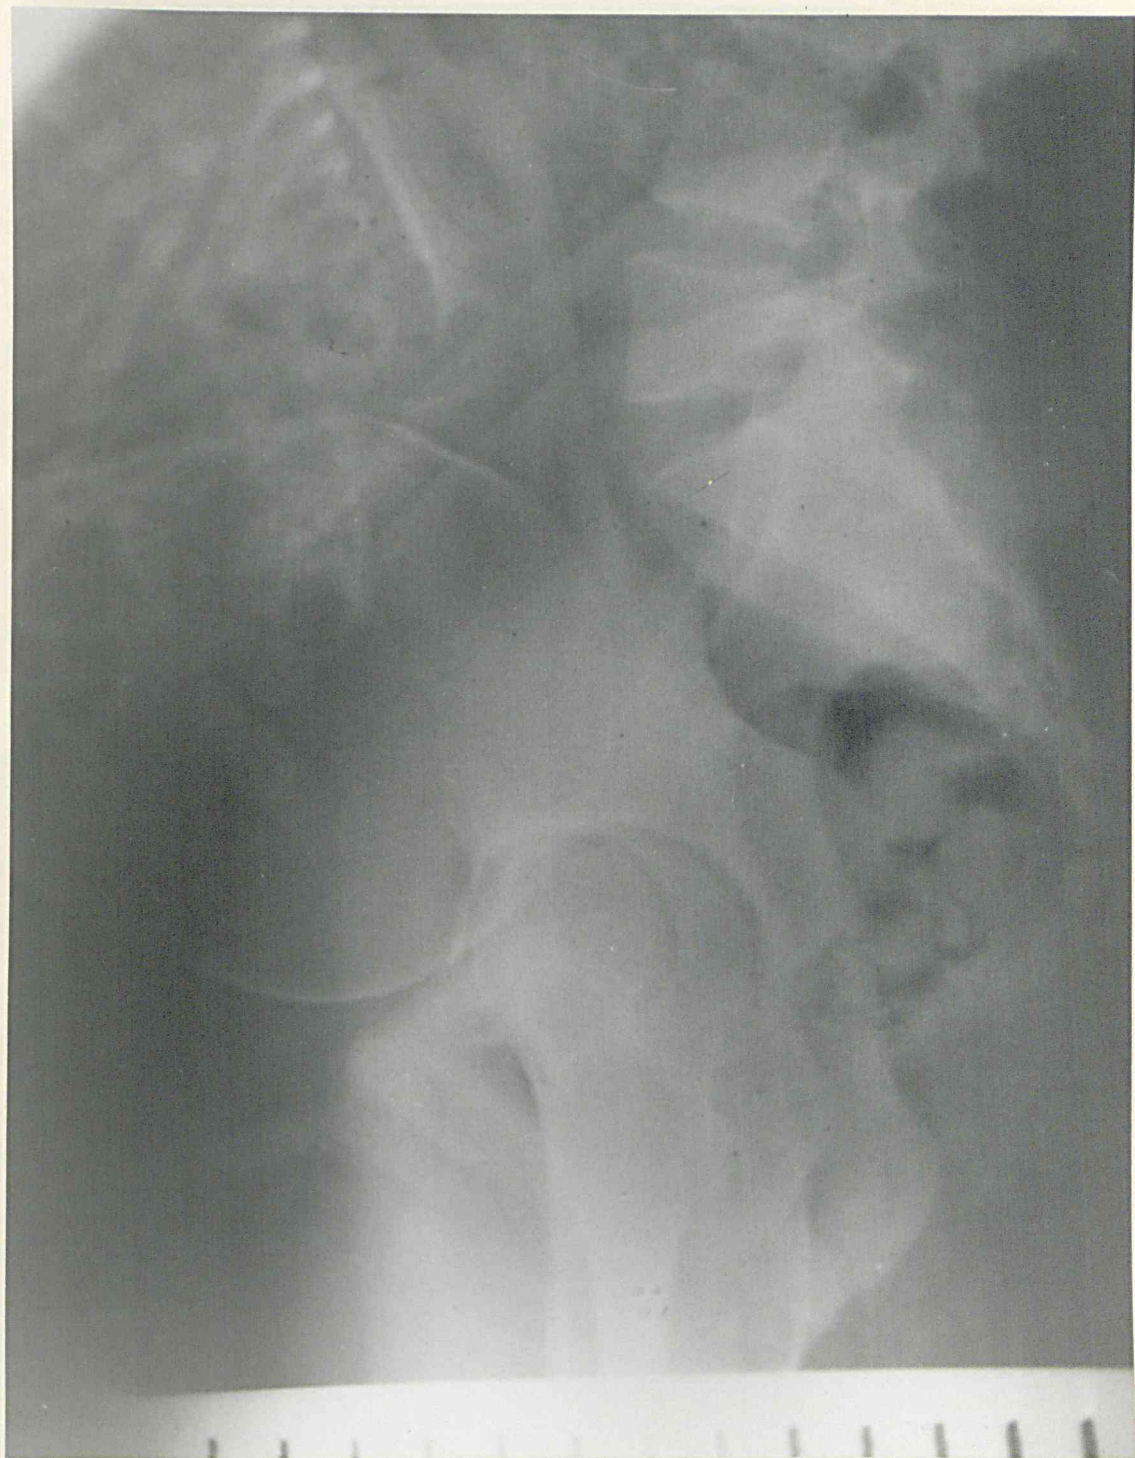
Erect lateral radiograph of the pelvis. The posterior "band-like" shadow is very well defined, but the thicker anterior "band-like" shadow is much less clearly seen. (Case No. 244).
